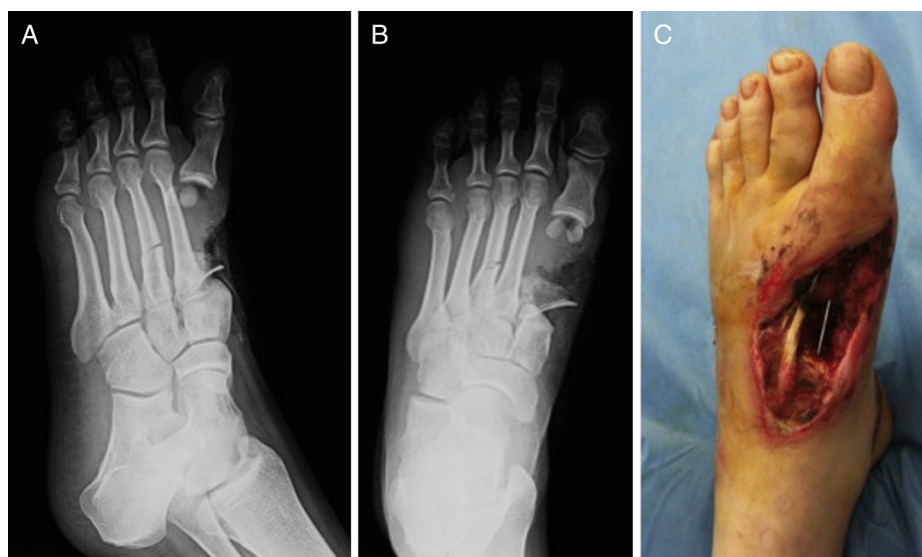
Preoperative (A) oblique and (B) anteroposterior radiographs and (C) dorsal clinical view of the injured left foot after initial debridement and Kirschner wire fixation.
